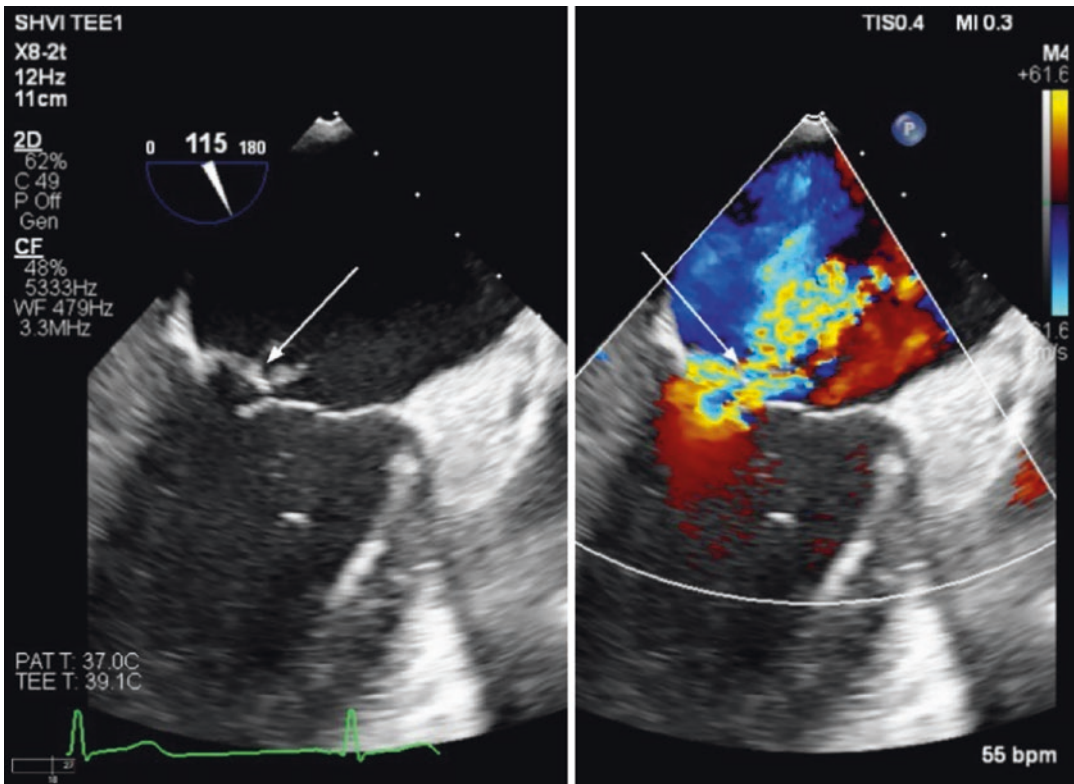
Flail P2 segment left arrow. The ruptured cord and leaflet tip is pointing back into atria which is the hallmark of a flail leaflet. Severe 4 + primary MR on color doppler is shown by the arrow in the right panel
